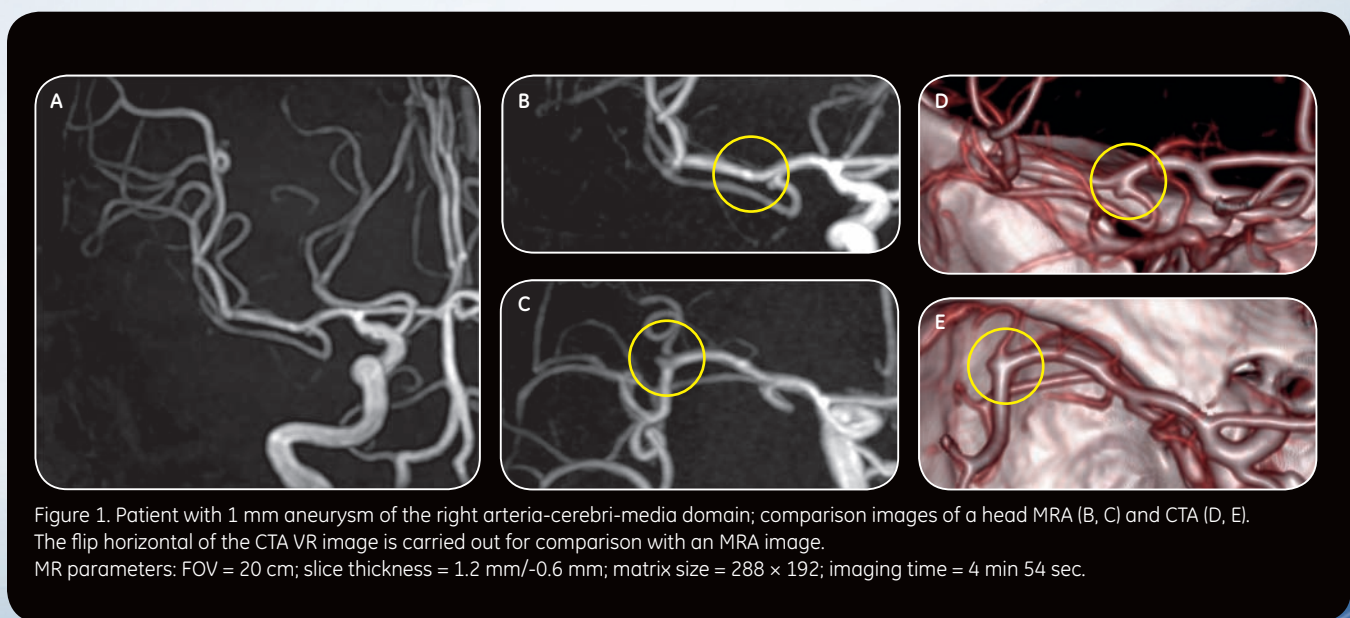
Patient with 1 mm aneurysm of the right arteria-cerebri-media domain; comparison images of a head MRA (B, C) and CTA (D, E). The flip horizontal of the CTA VR image is carried out for comparison with an MRA image. MR parameters: FOV = 20 cm; slice thickness = 1.2 mm/-0.6 mm; matrix size = 288 × 192; imaging time = 4 min 54 sec.
